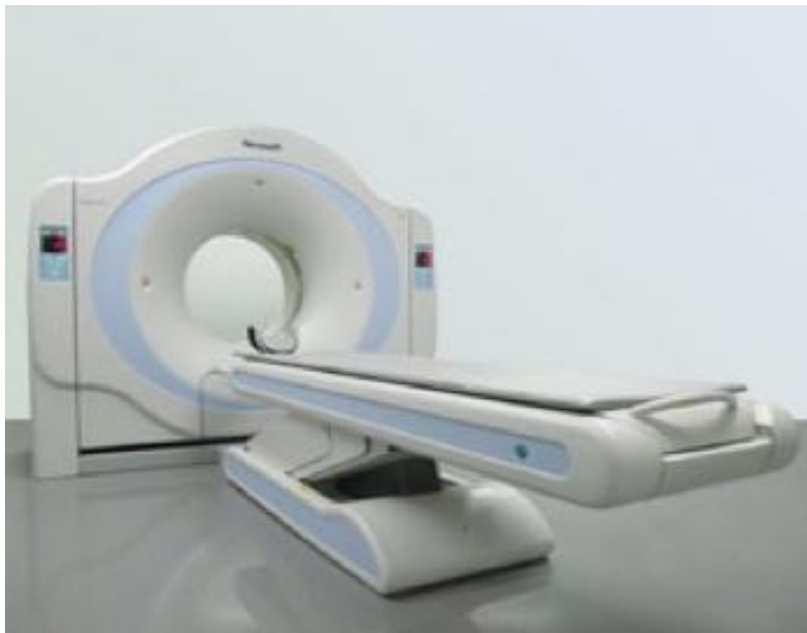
computed tomography equipment 64 slices.
